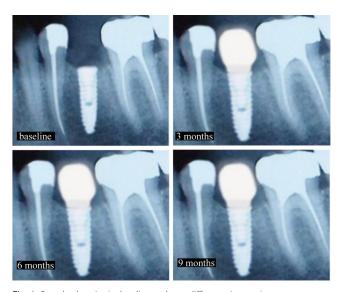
Standard periapical radiographs at different time points (baseline, and 3, 6 and 9 months postoperatively)
